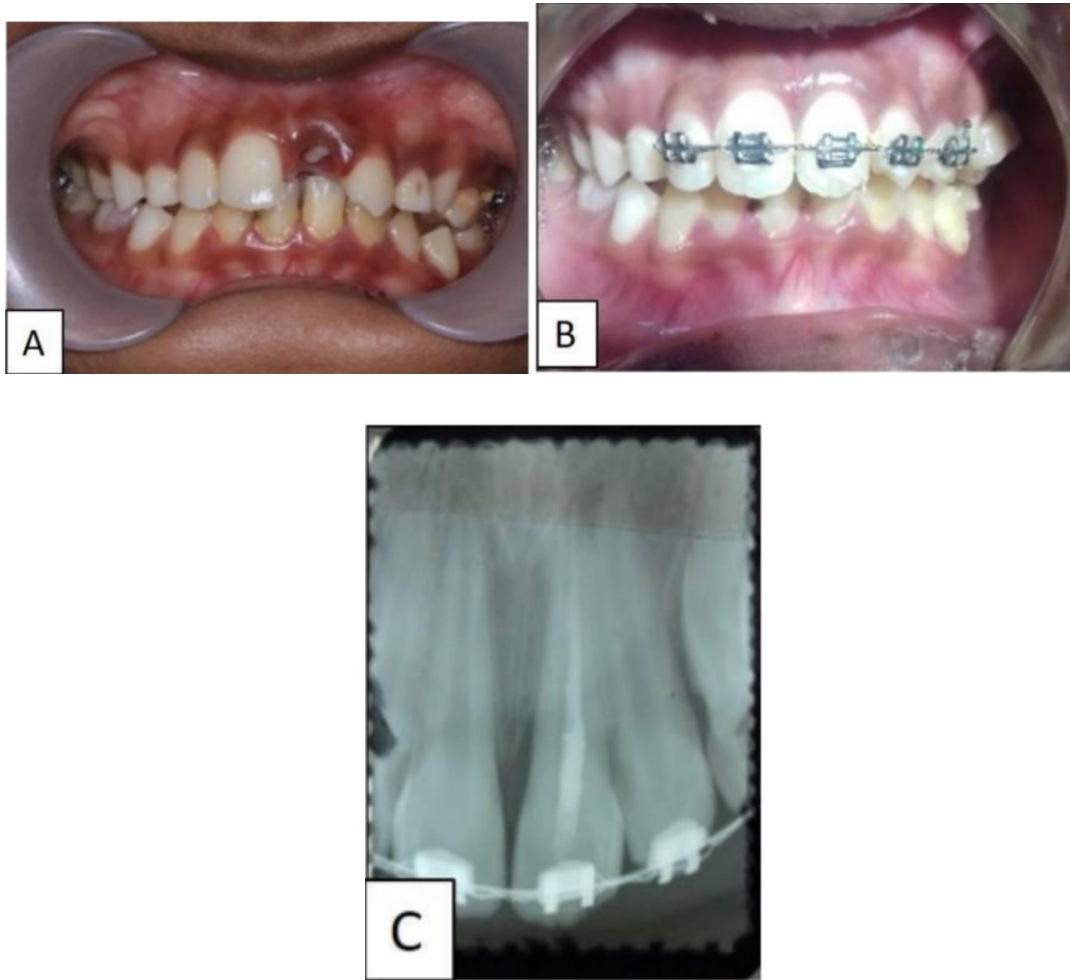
(a) Intra Oral Examination before treatment in the first case; (b) Intra Oral Examination after treatment using orthodontic appliance; (c) 3-month evaluation periapical radiographs (Wahluyo *et al.*, 2018).
